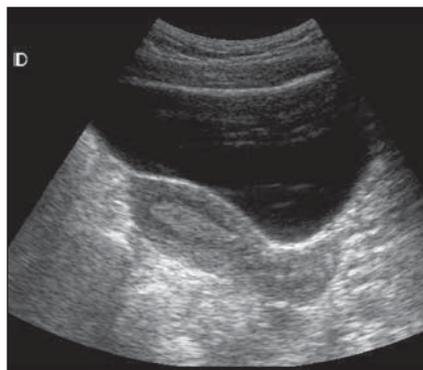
Longitudinal view of a normal uterus on 2D transabdominal ultrasound. Observe the adequately filled bladder, and the secretory pattern of the endometrium.
